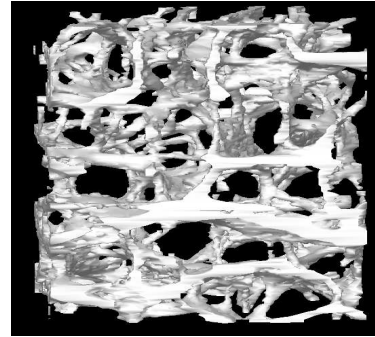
A Micro Computed Tomographic 3D image
